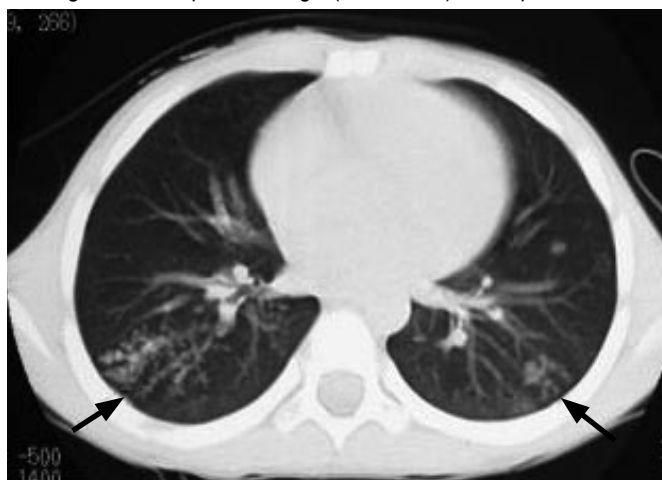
Axial CT image shows bilateral nodular opacity in both right and left lower lobes (black arrows).
